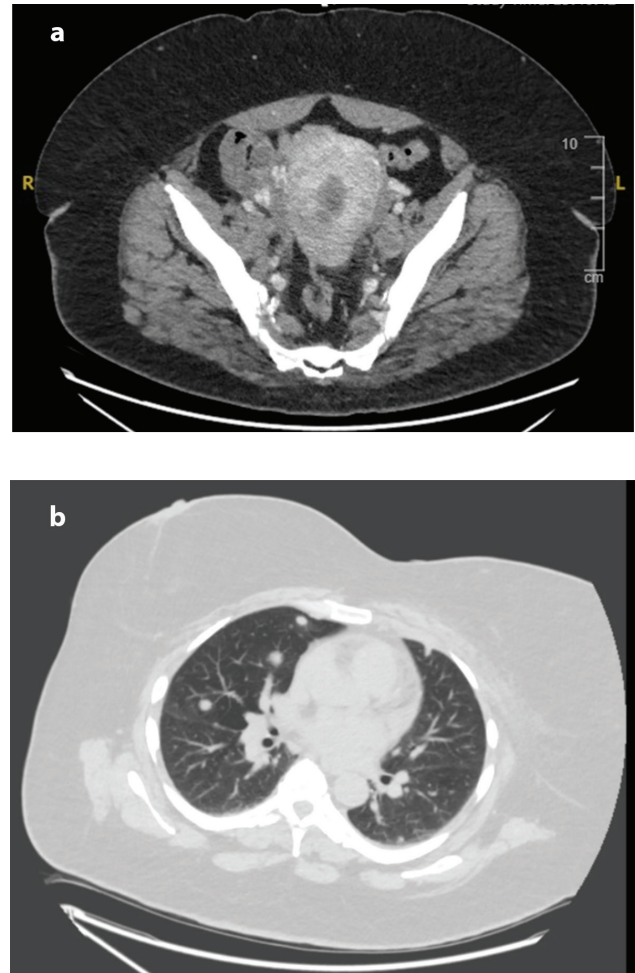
(a) CT scan at the level of the pelvis showing the cervical mass (shown in green arrow) with pelvic lymphadenopathy (shown with yellow arrow); (b) at the thorax in lung window show metastatic deposits in the right lung marked with red arrows.
